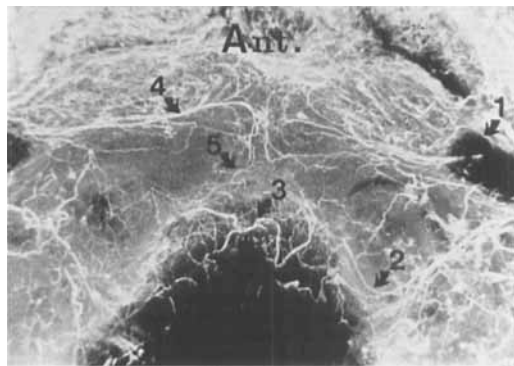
Sagittal section through the odontoid process. Radiograph of Spalteholtz preparation. (cf. Figure 4 a, no. 3, slice thickness 5 mm).
